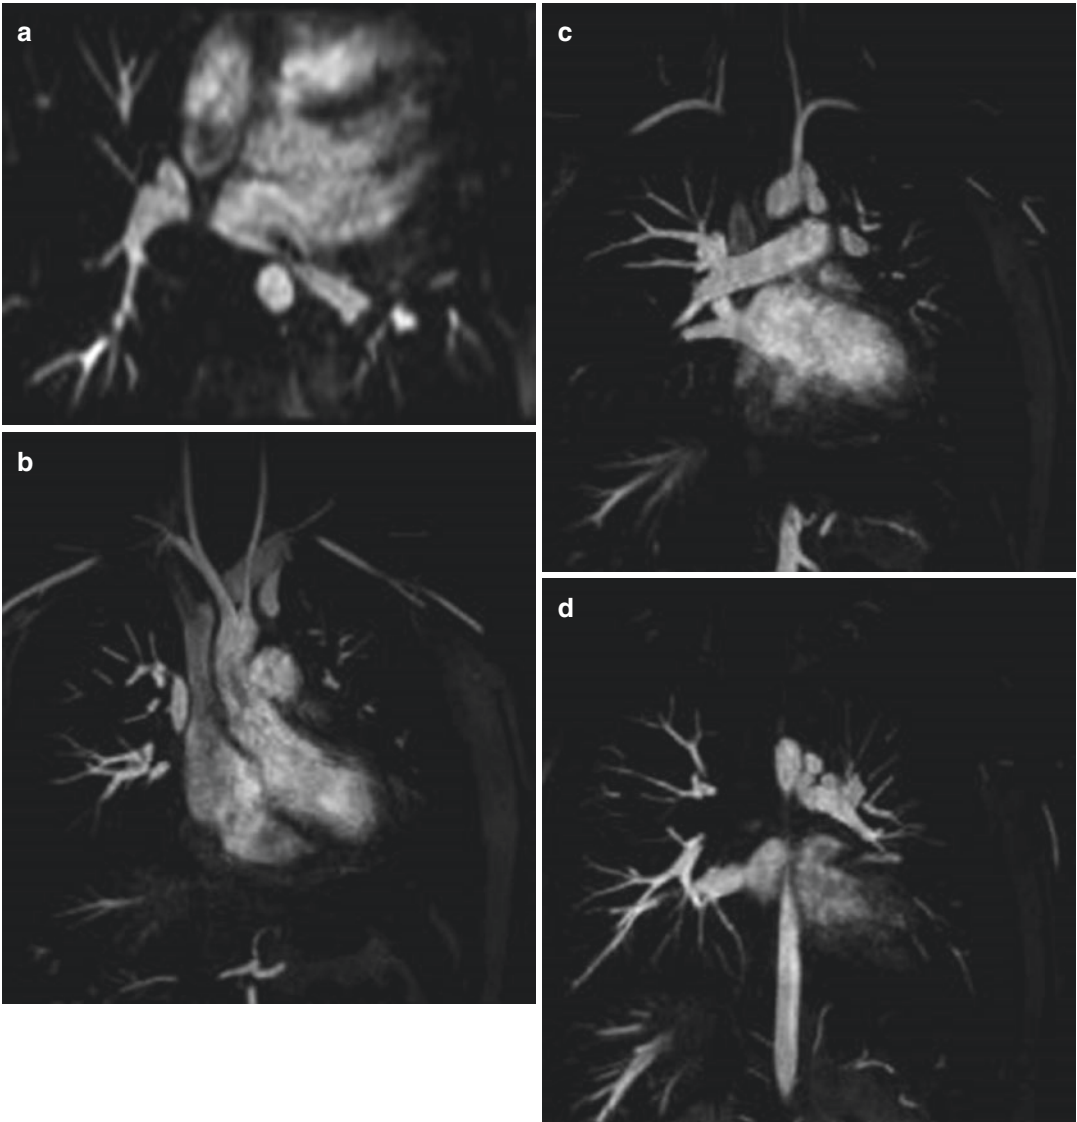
Left pulmonary vein stenosis at cardiac MRI. (a) Axial oblique view image obtained from cine TruFISP MRI sequence shows a severe stenosis involving the left common pulmonary vein. (b)–(g) Coronal thin maximum intensity projection and (h) posterior volume rendering
